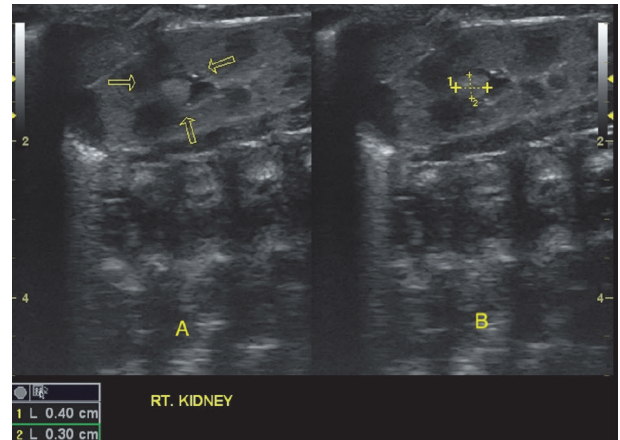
Ultrasonographic assessment of fourth patient performed at 26 days of life demonstrating a hyperechogenic oval image suggestive of a fungal ball in the middle calyx group of the right kidney (delimited by the yellow arrows in A and being measured by the calipers in B).
